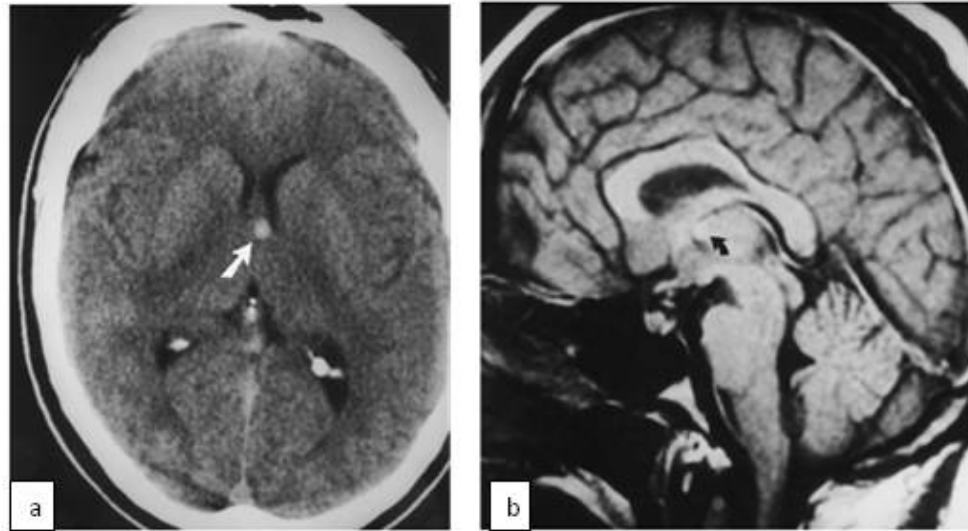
10. Images of a patient diagnosed with colloid cysts. a) Axial unenhanced CT scan shows a high attenuation colloid cyst, b)Sagittal MR image shows the colloid cyst (arrow) [19].
